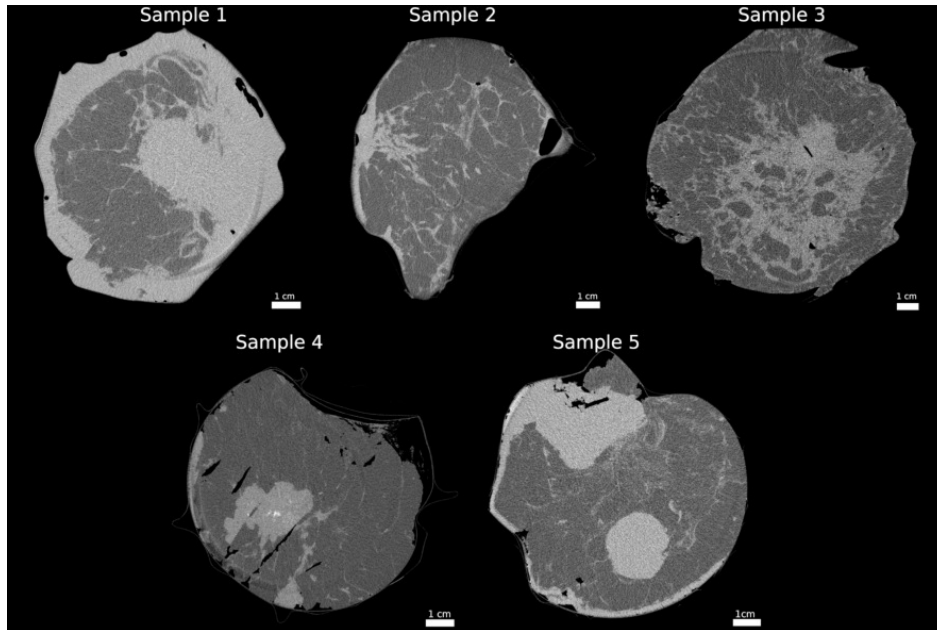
Mastectomy CT reconstructions acquired at SYRMEP beamline at Elettra Sincrotrone Trieste at the energy of 28 keV (Sample 1,2,3, and 5) and 26 keV (Sample 4).
